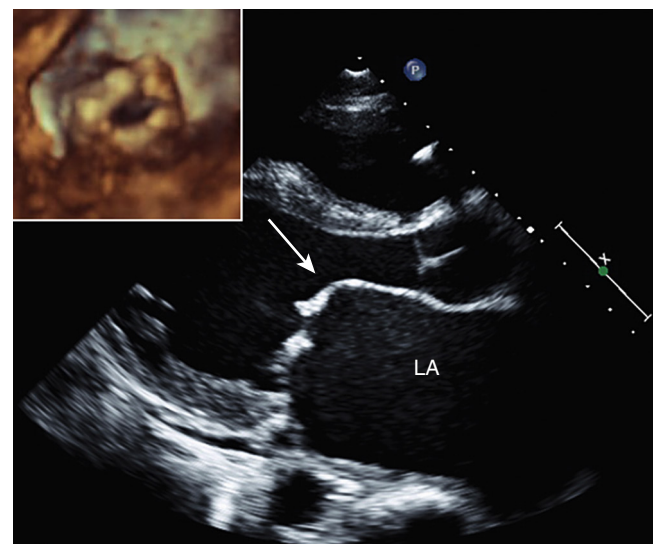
Rheumatic mitral stenosis. Parasternal long-axis view (diastolic frame) of a rheumatic mitral valve. Diastolic doming of the anterior mitral leaflet (arrow) is present, as well as a fixed posterior leaflet. *Inset*, Doming and fish-mouth appearance of the valve, as seen by 3D TTE from the LV aspect. LA, Left atrium. (See Videos 16.35 and 16.36.)
